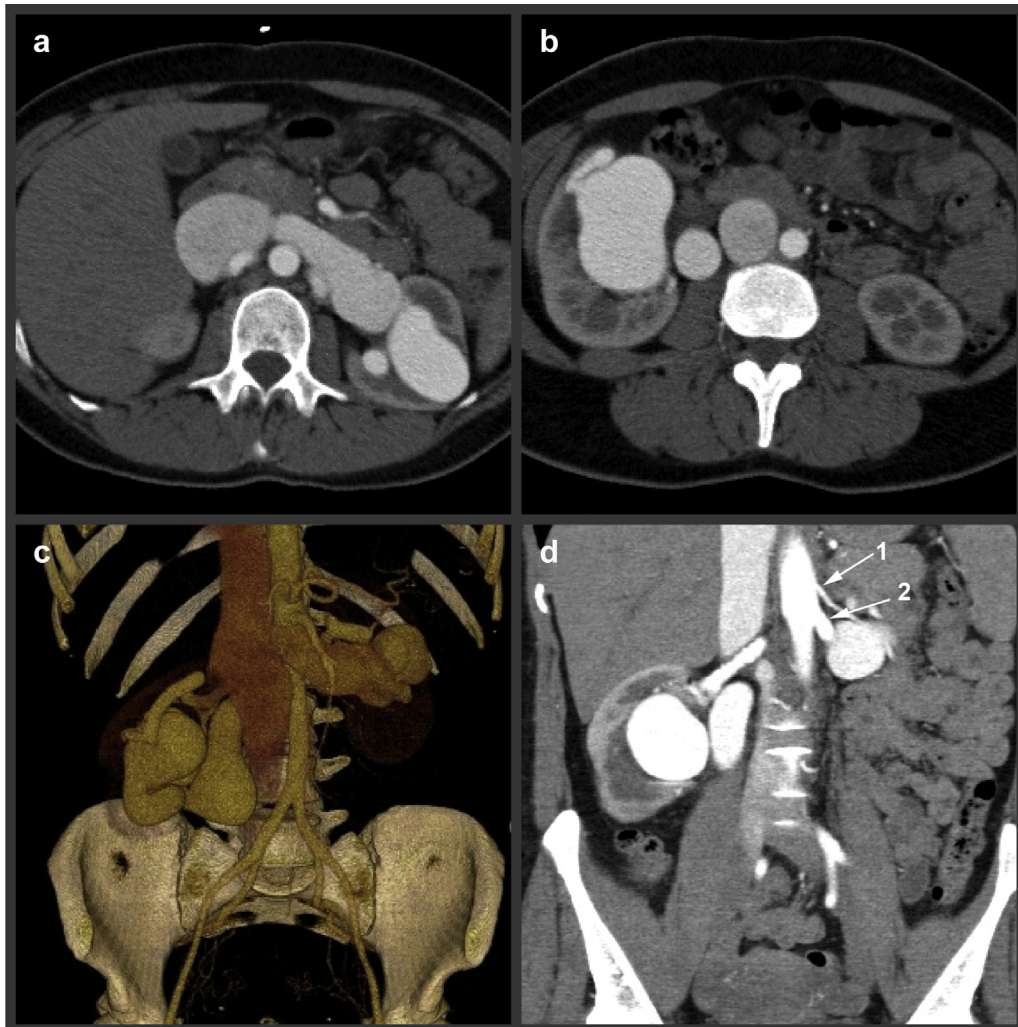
Computed tomography (CT) angiography of bilateral arteriovenous fistula (AVF). a and b, Axial images and (c) the volume-rendered image show aneurysmal dilatation of both renal arteries and veins with early contrast enhancement of the renal veins and inferior vena cava. d, The coronal reformation reveals the left lower pole renal artery (1) and the left upper pole renal artery (2).
